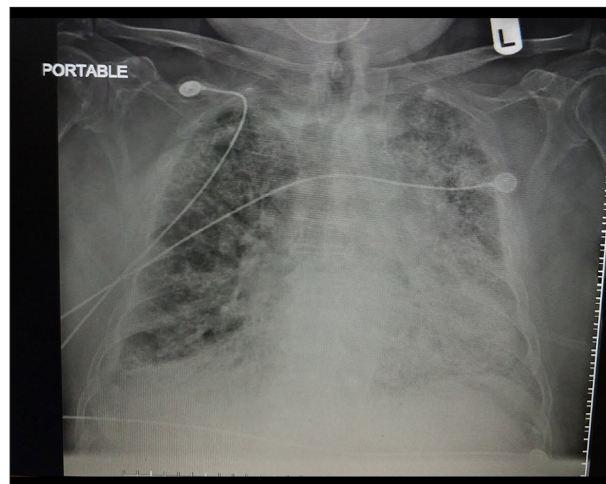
Portable chest X-ray (anteroposterior) shows an increased cardiothoracic index and interstitial edema.
